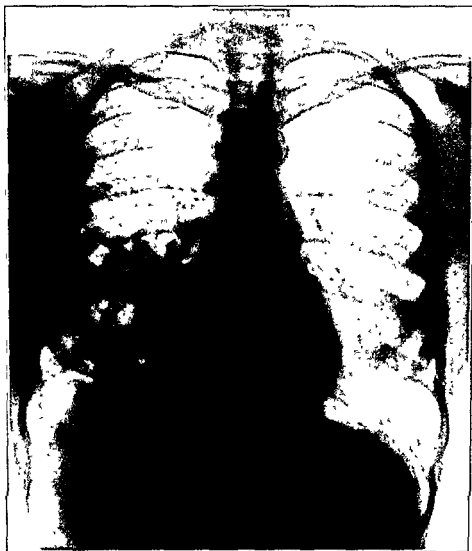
An x-ray of a young female (Case No. 1) with an exudative tuberculosis in the lower half of the right lung. The disease is in the process of resolution.
